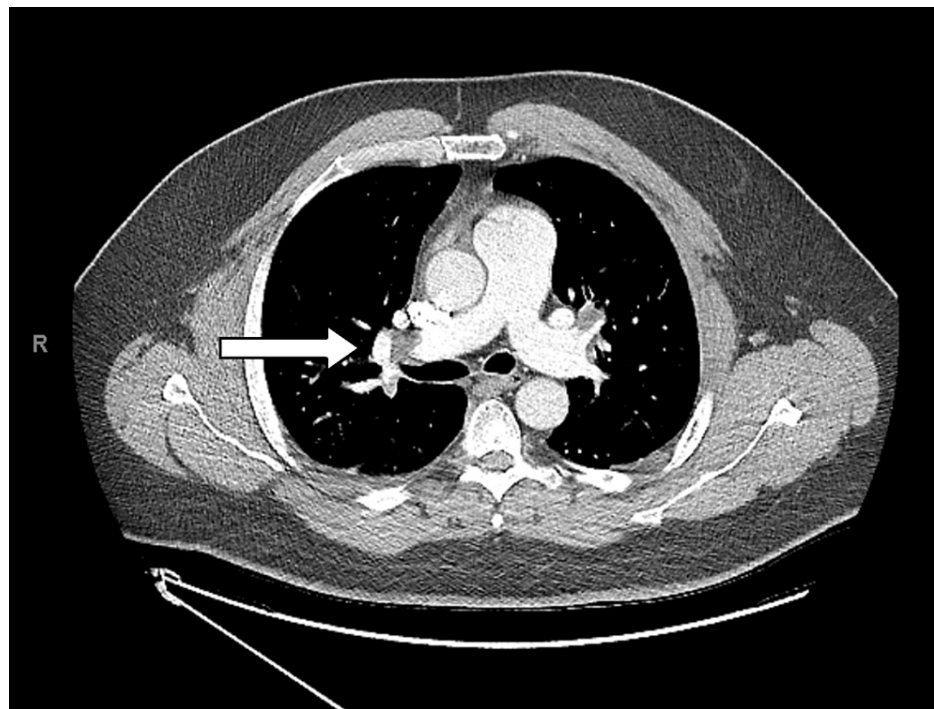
Computed tomography angiography (CTA) showing pulmonary embolism in the distal right pulmonary artery.
